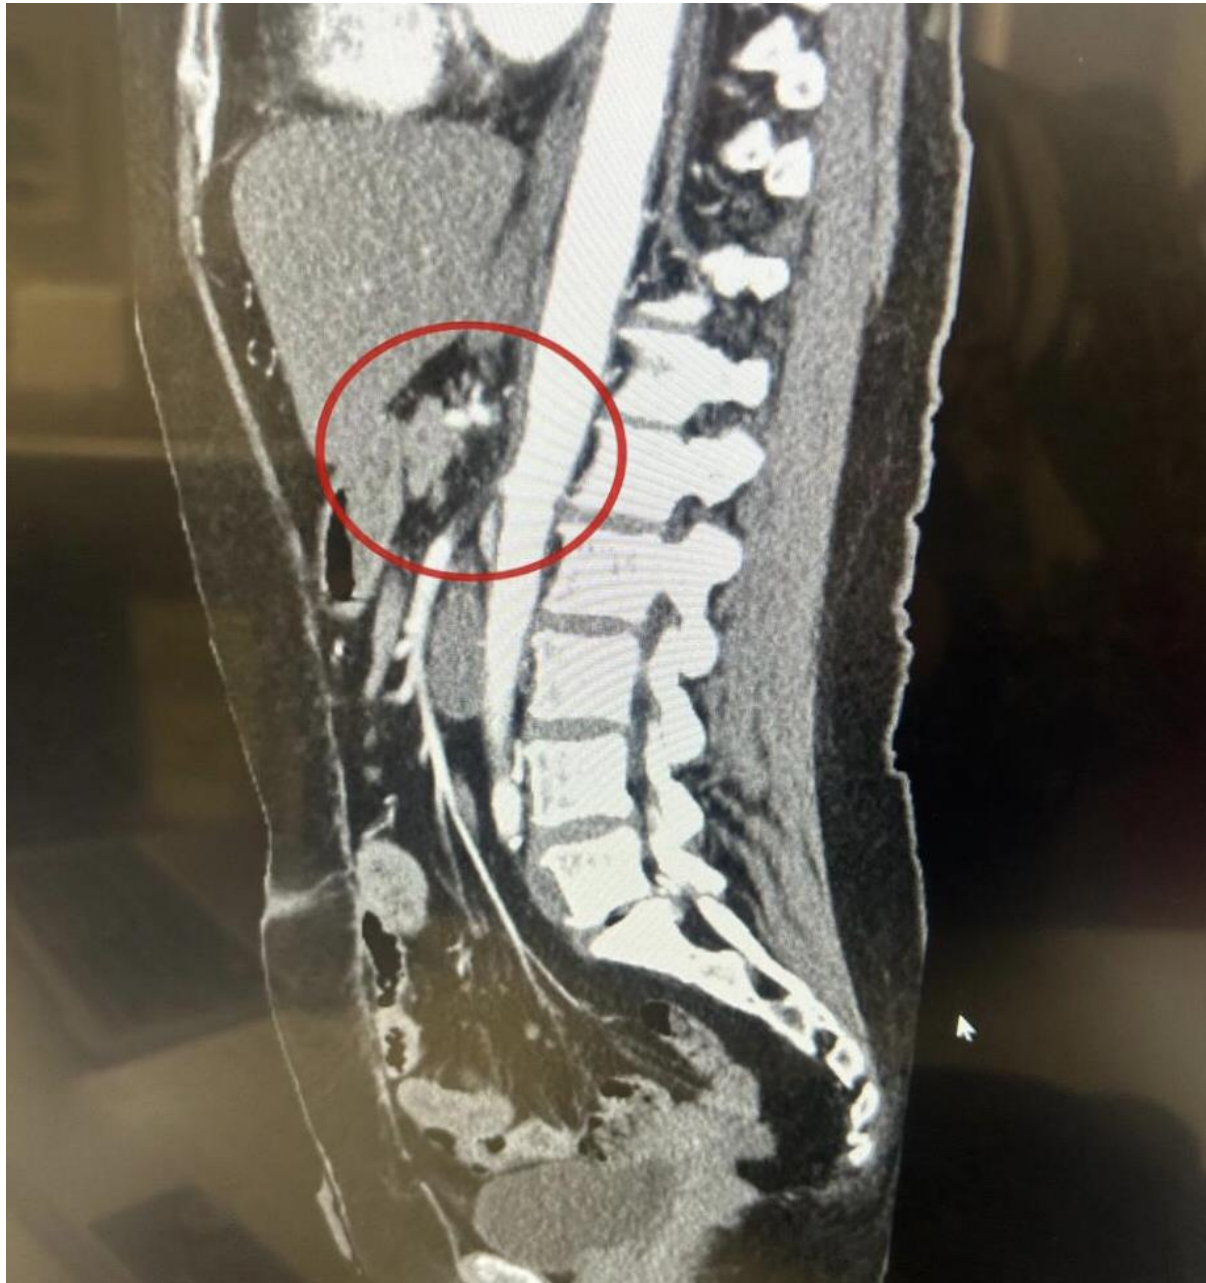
Initial abdominal CT angiogram showing significant luminal narrowing at both the origin of the celiac axis in and superior mesenteric artery
